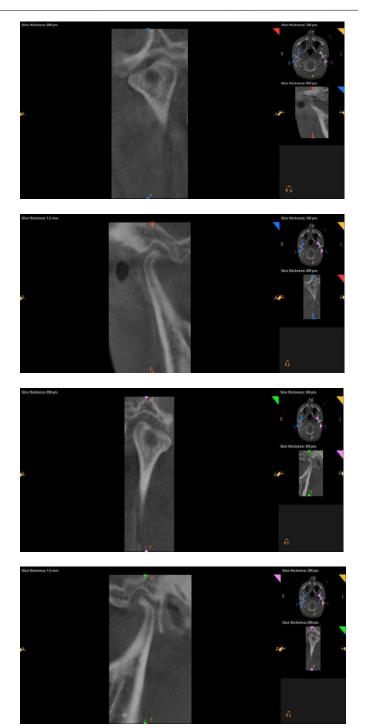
and 3B Coronal section of CBCT of right side and Figure 3C and 3D coronal section of CBCT of left side showingsignificant reduction in the dimensions of right and left condyles and thinning out of the condylar neck is also evident with decrease in the intra-articular space on the left side
